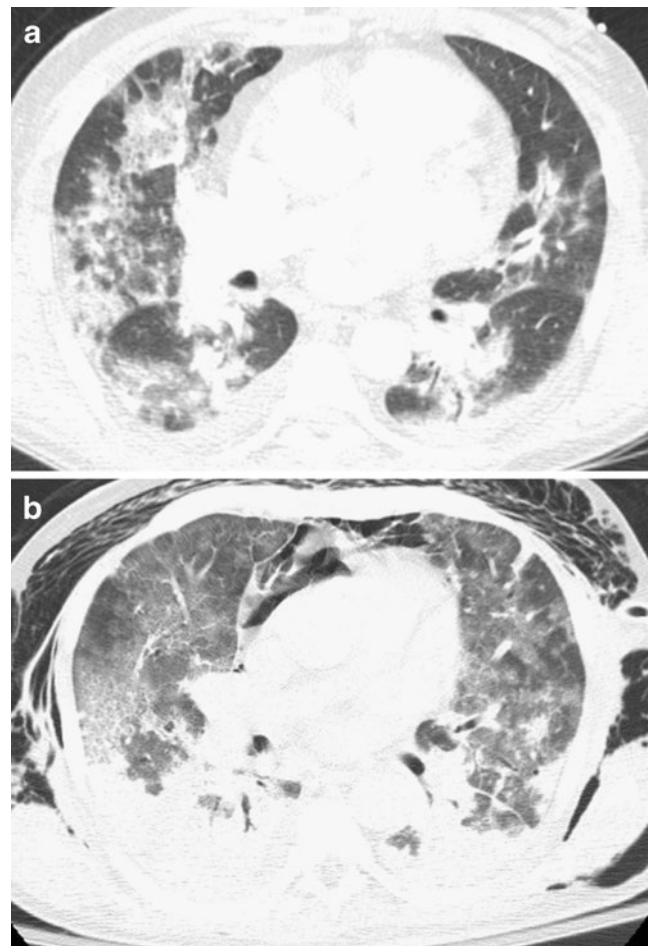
A 66-year-old man with novel influenza A (H1N1), diabetes, and renal failure. a Axial CT demonstrates extensive, patchy bilateral GGO and consolidation without a distinct peribronchial or subpleural distribution. b Follow-up CT demonstrates worsening of dependent consolidation, primarily in the lower lobes. While there has been improvement in some of the non-dependent regions of consolidation, the patient has developed more confluent GGO, typical of diffuse alveolar damage. This patient also has pneumomediastinum from alveolar rupture
